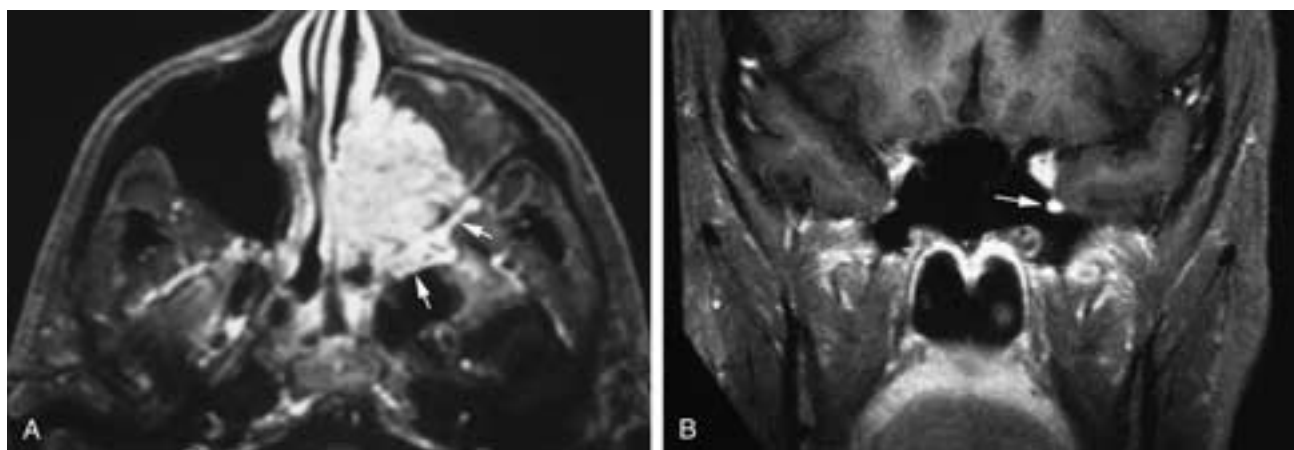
Axial (A) and coronal (B) T1-weighted, fat-suppressed, contrast-enhanced images. (A) A destructive mass in the left nasal fossa and maxillary sinus with tumor in the left pterygopalatine and infratemporal fossae (arrows). In B the left second division of the trigeminal nerve (arrow) is enlarged and enhanced, signifying perineural tumor extension. This patient had a squamous cell carcinoma.
